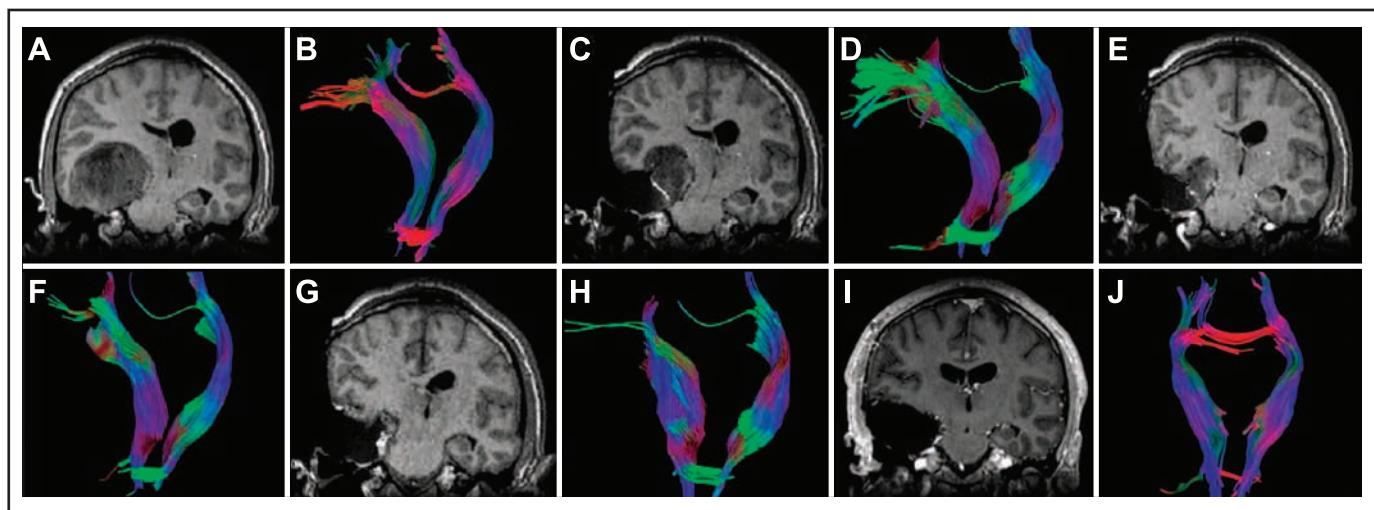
Diffusion tensor imaging highlighting the displacement of white matter fibers away from a mass obtained intraoperatively in a right temporal oligoastrocytoma WHO grade 3 in a 29 year old male patient. (A, C, E, G, I) T1-weighted coronal MRI scans obtained intraoperatively; (B, D, F, J) tractography of the pyramidal tracts. (A, B) preoperative; (C, D-H) during tumor research with G and H after completed tumor removal; (I, J) 3 months after surgery. Red, right/left direction of fibers; green, anterior/posterior; blue, superior-inferior. The color code for the intraoperatively obtained tractograms (D, F, H) has right/left and anterior-posterior switched because of the horizontal placement of the head for surgery. Adapted with permission.⁴⁷
